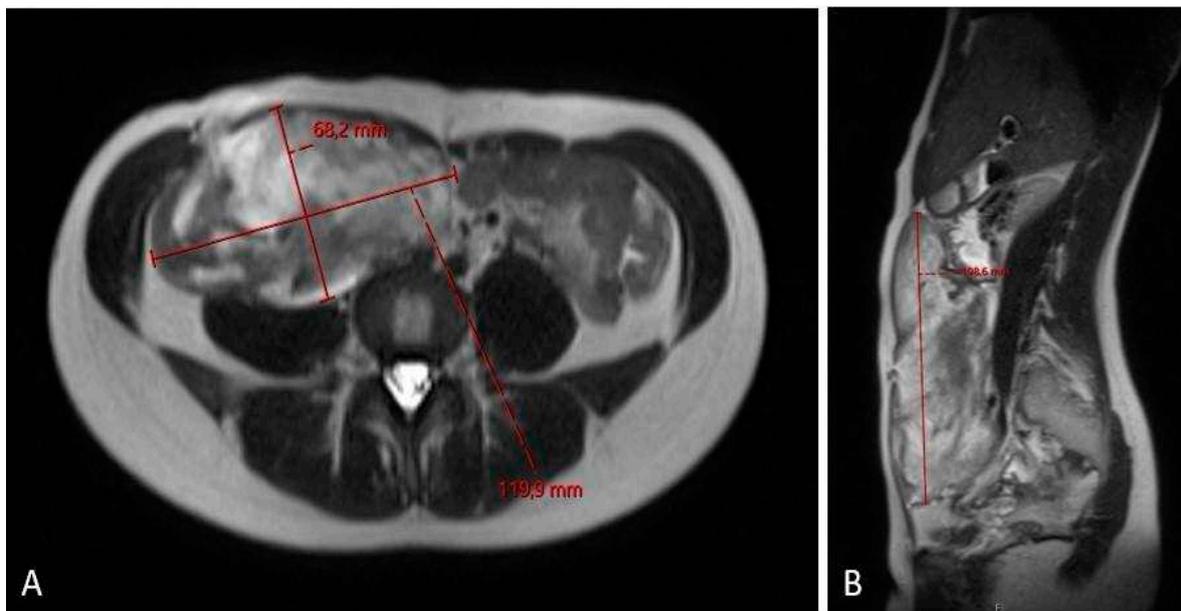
MRI scan (A – axial plane; B – sagittal plane) after 3 cycles chemotherapy showing no effect of the treatment and slightly progression in the cranio-caudal tumor size (12 x 6.6 x 20 cm).
